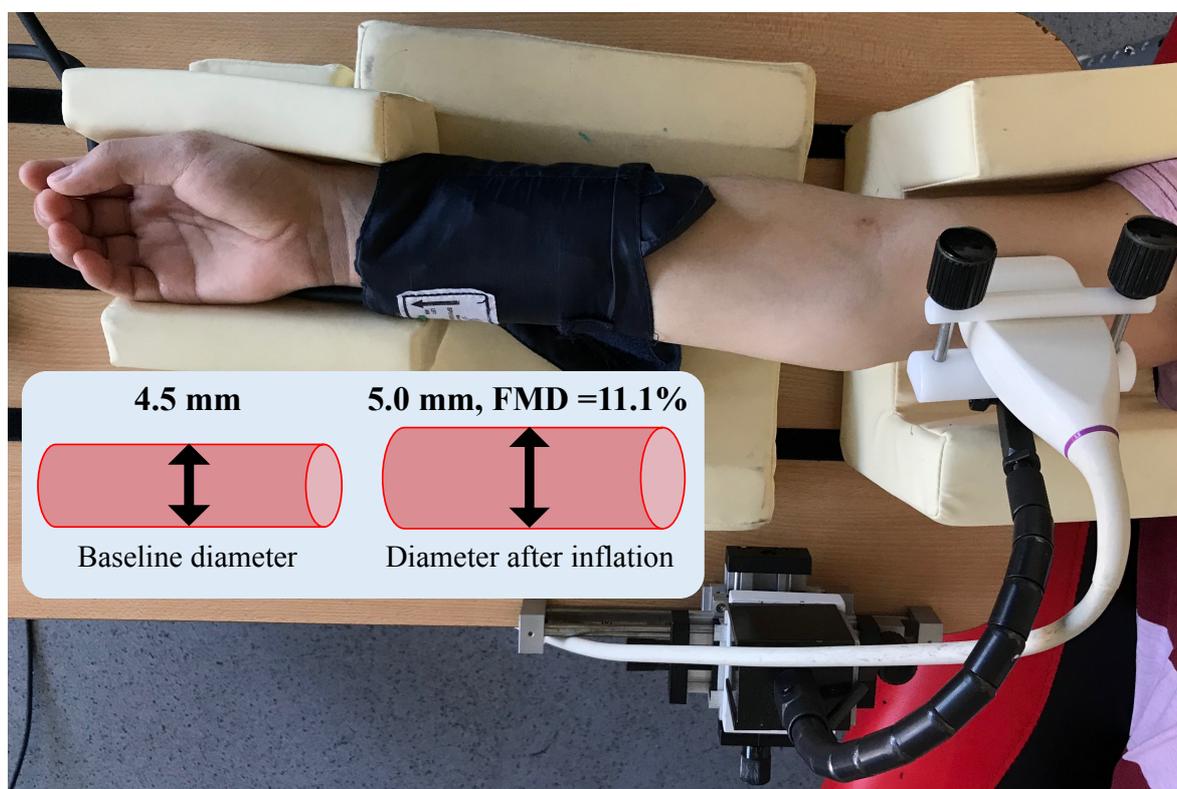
Ultrasound imaging of the brachial artery with upper versus lower cuff placement and transducer position above the antecubital fossa.*
